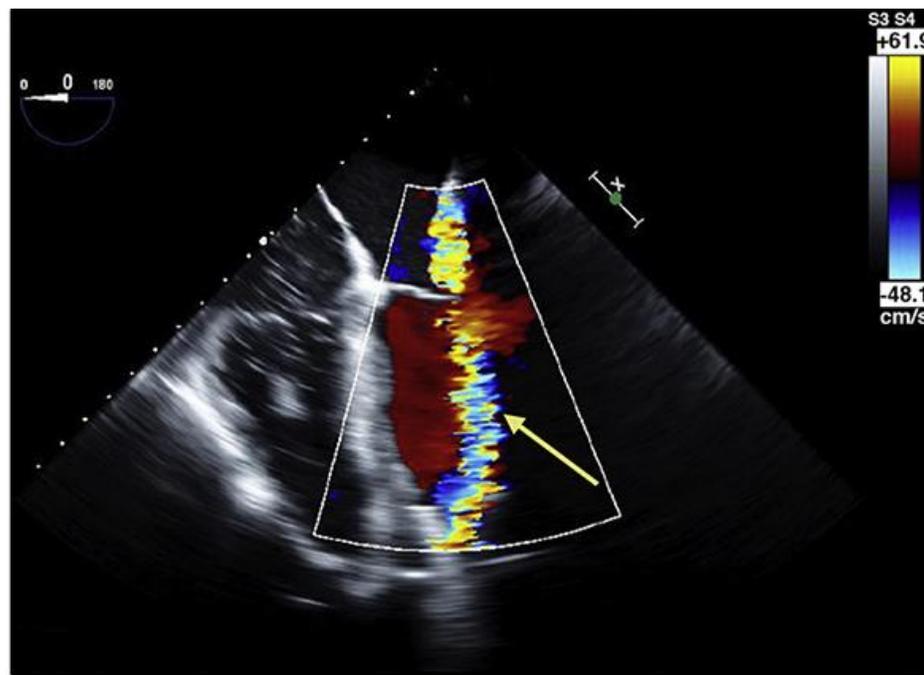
Transesophageal echo: the turbulent pattern is due to a reverberation artifact and occurs when inflow and rotor are directly opposite of the ultrasound beam source. From Magunia et al.(4), with permission.
